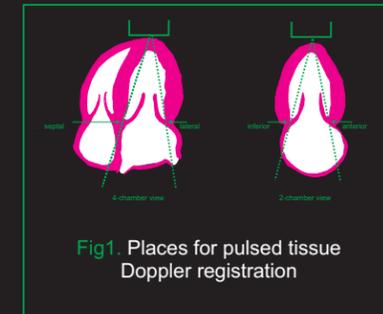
Places for pulsed tissue Doppler registration
